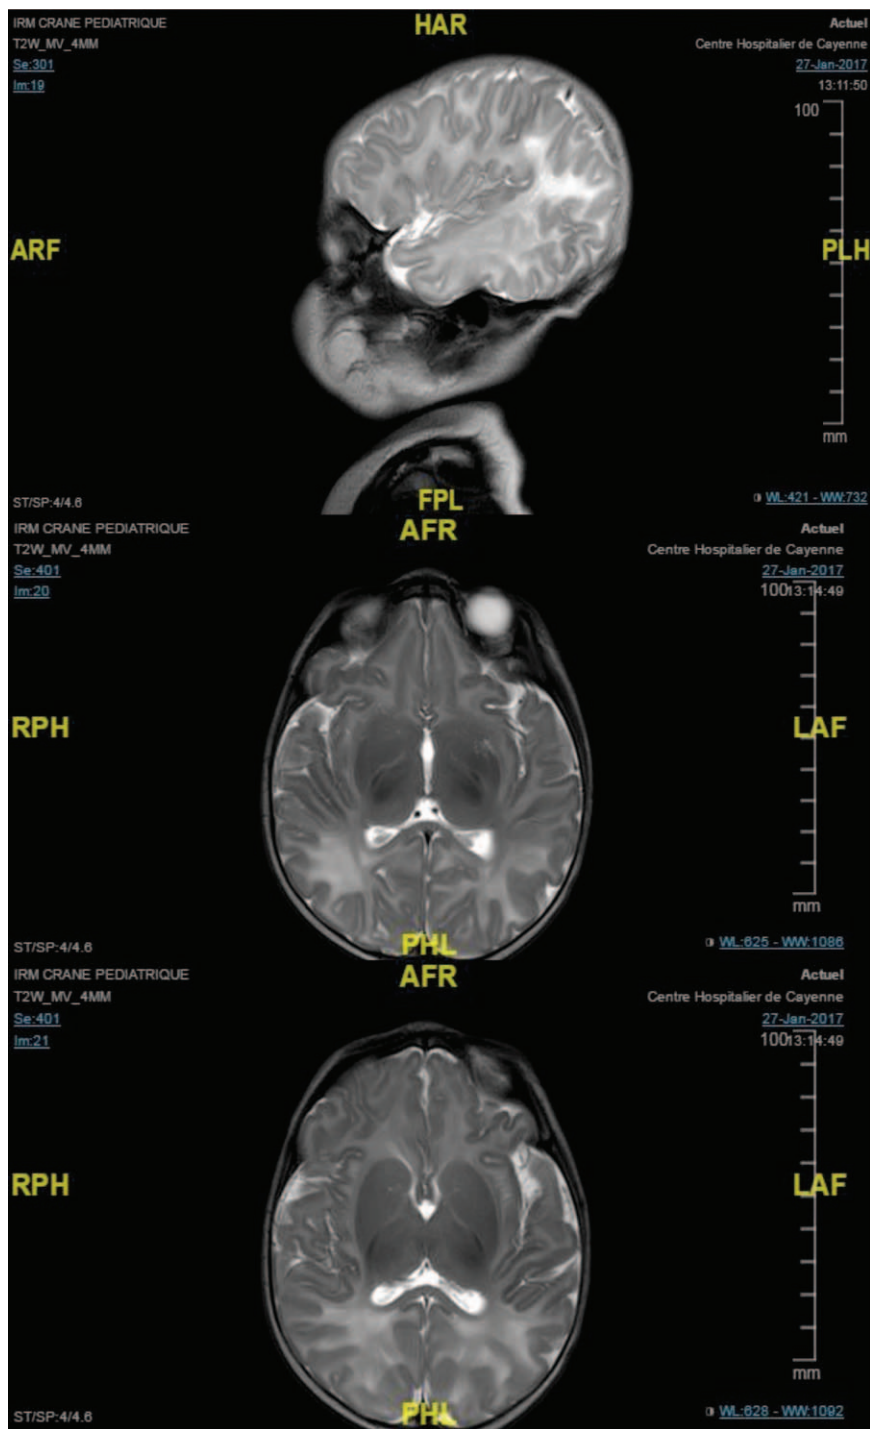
Patient number 2: Cerebral MRI showing diffuse white matter hyperintensity in occipital areas. T2 sequence. MRI=magnetic resonance imaging.
